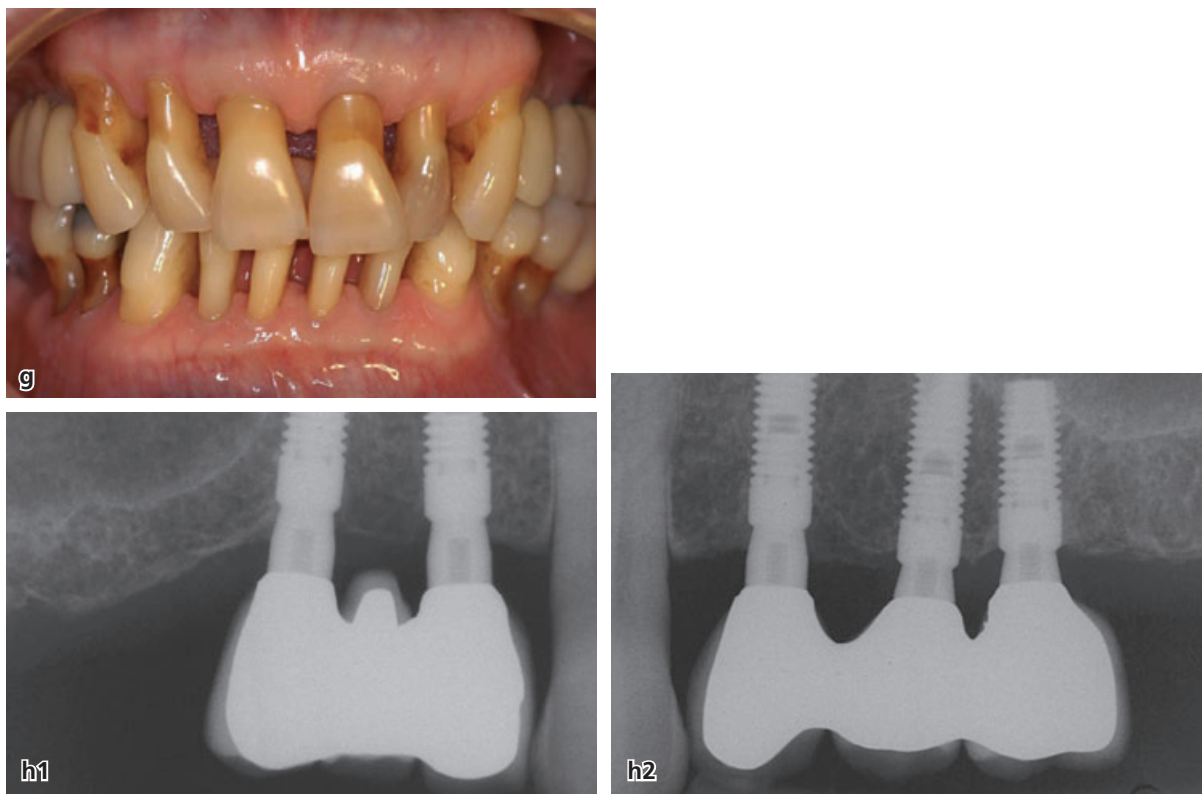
(g,h) Clinical and radiographic status of patient H.L. 10 years after completion of the implant treatment. Note that there is no loss of bone support at the implants.
